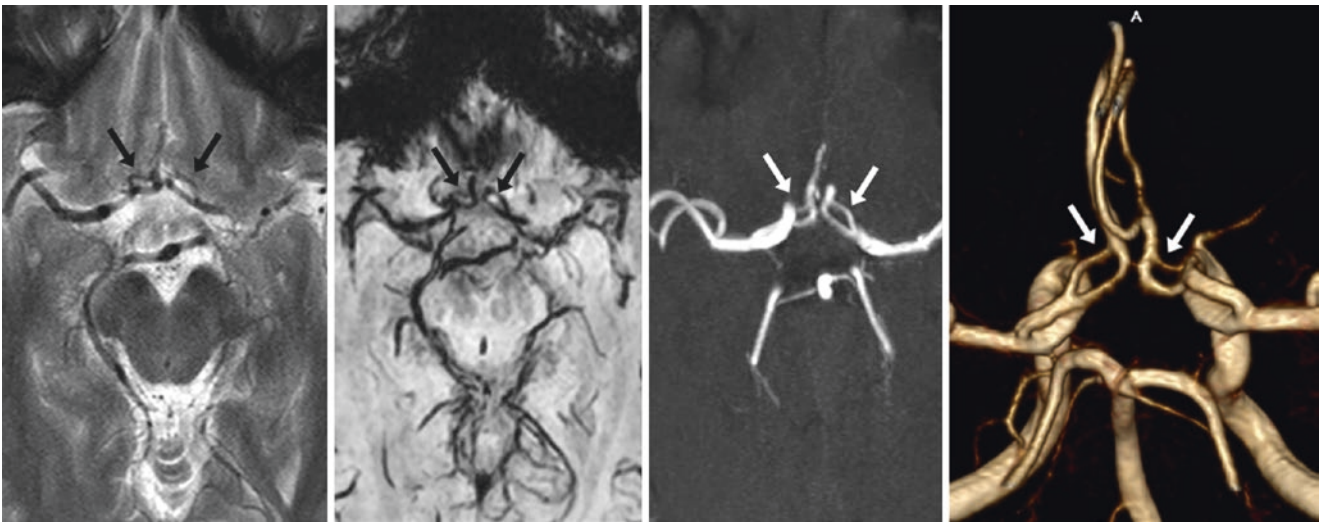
41-year-old with bilateral ACA A1 segment fenestrations (*arrows*) on 3 T MRI axial T2WI (*left*), SWI (*left middle*), 3D TOF MRA 5 mm-thick MPR (*right middle*), and on a 3D VR superior view (*right*) from the 3D TOF MRA
